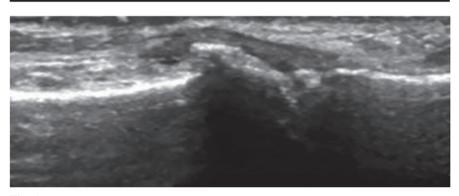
Ultrasound of the third proximal interphalangeal joint in hand OA, showing the presence of osteophytes and synovial hypertrophy.
